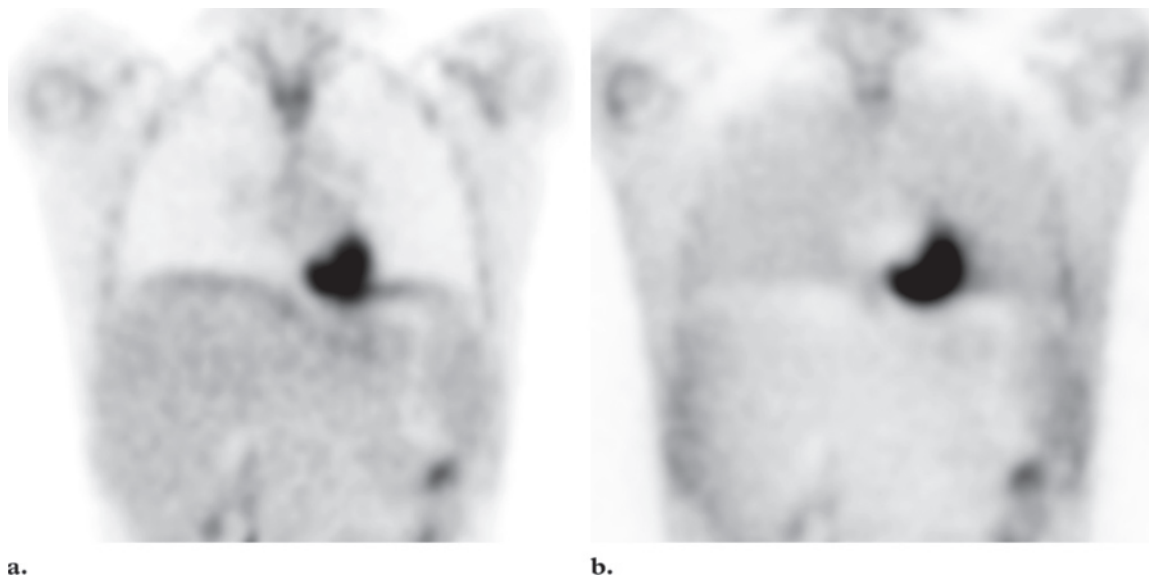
Respiratory motion artifact. (a) Coronal attenuation-corrected FDG PET scan shows bilateral curvilinear uptake along the domes of the diaphragm. (b) Coronal non-attenuation-corrected FDG PET scan shows no abnormally increased activity, a finding that, along with the fact that there was no corresponding CT abnormality, confirms that the diaphragmatic uptake seen in a represents respiratory motion artifact.
